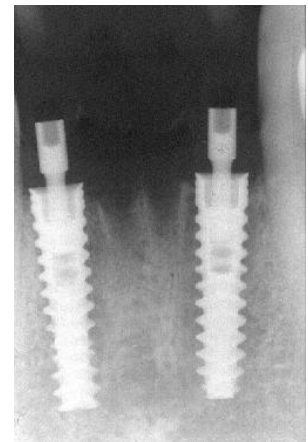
Periapical radiograph performed immediately after implant placement in the incisor lower jaw area.*
